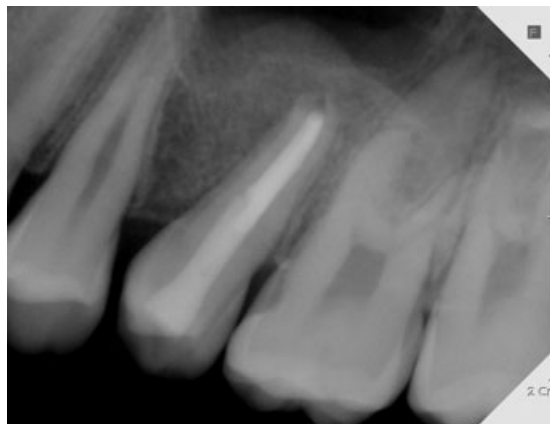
Radiograph taken after canal filling (at 5 months after surgery), showing the completion of canal filling and the application of a resin core.
